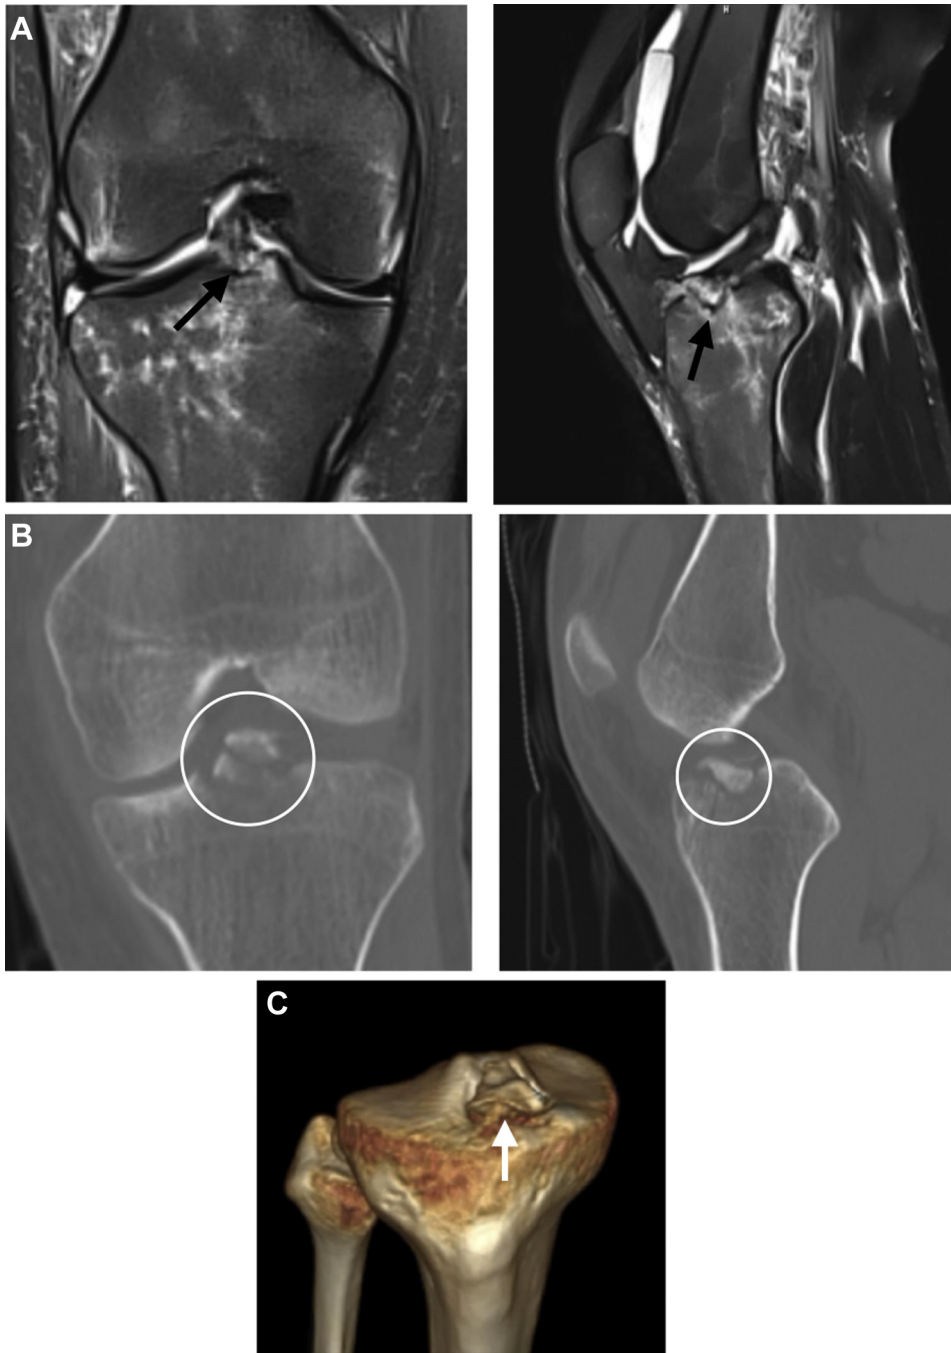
(A) Coronal and Sagittal T2 weighted MRI cuts of the right knee (a) confirm the integrity of the ACL (black arrow). Coronal and Sagittal CT images (b) best demonstrate the tibial eminence fracture (white circle) with adjunct three dimensional CT reconstruction (c) further representing the fracture (white arrow) and used to assist in surgical planning.
